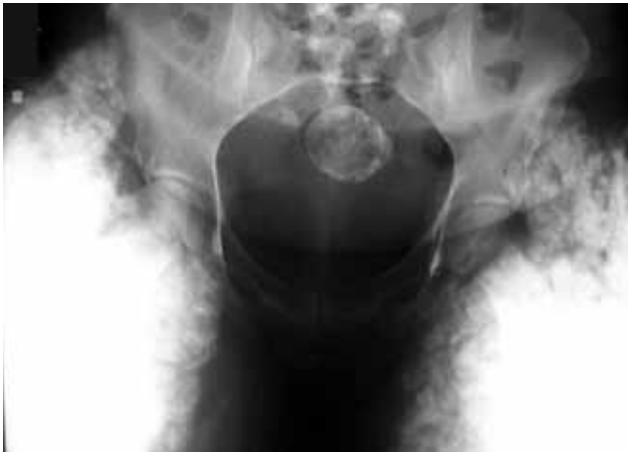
Plain anteroposterior radiograph of pelvis shows diffuse soft-tissue calcification in thighs bilaterally without involvement of hip joints.
